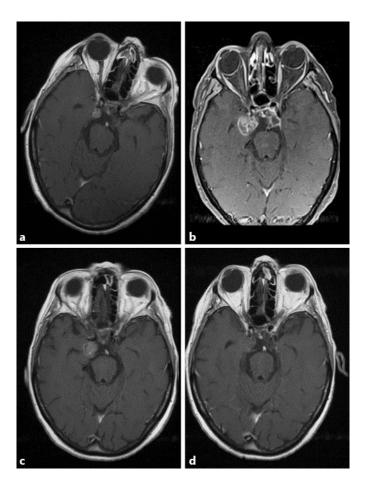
Comparative axial sections of cerebral MRI (T1 after gadolinium injection). a Before imatinib (August 2011). b After 800 mg/day imatinib for 5 months (January 2012). c After ertlotinib, 150 mg/day for 7 months (September 2012). d After erlotinib, 150 mg/day for 28 months (July 2014).
